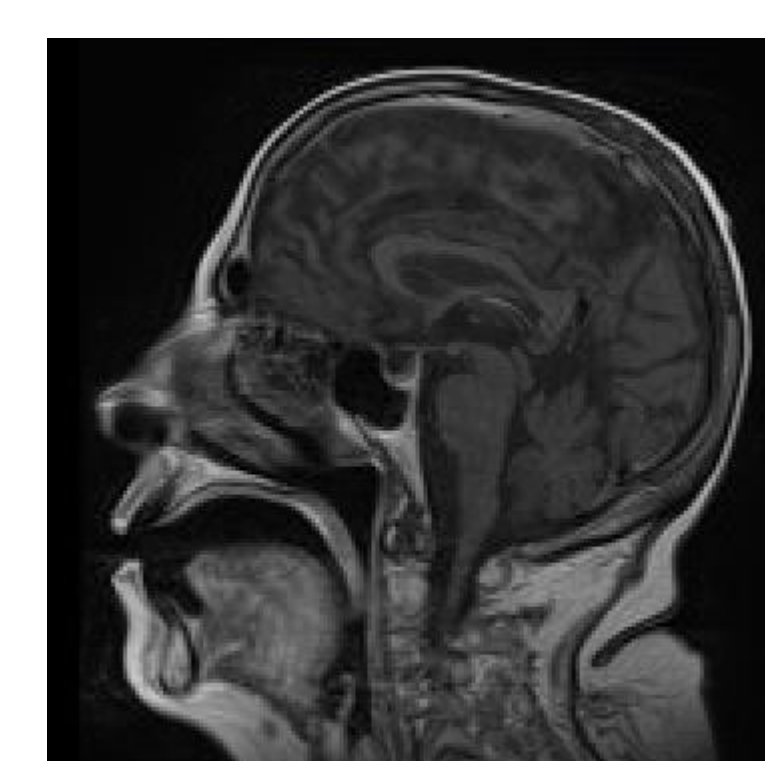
MRI Brain shows destructive lesion at left clivus and foramen magnum.
